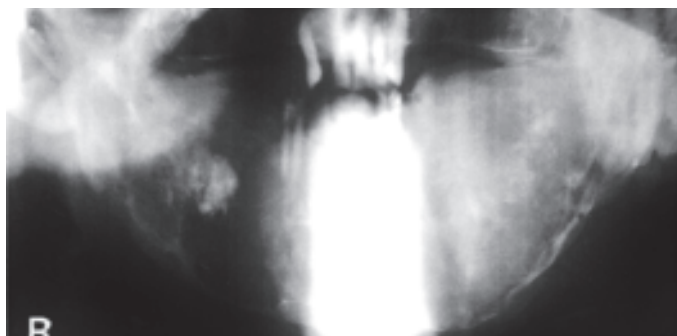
Radiographic appearance of monostotic fibrous dysplasia
